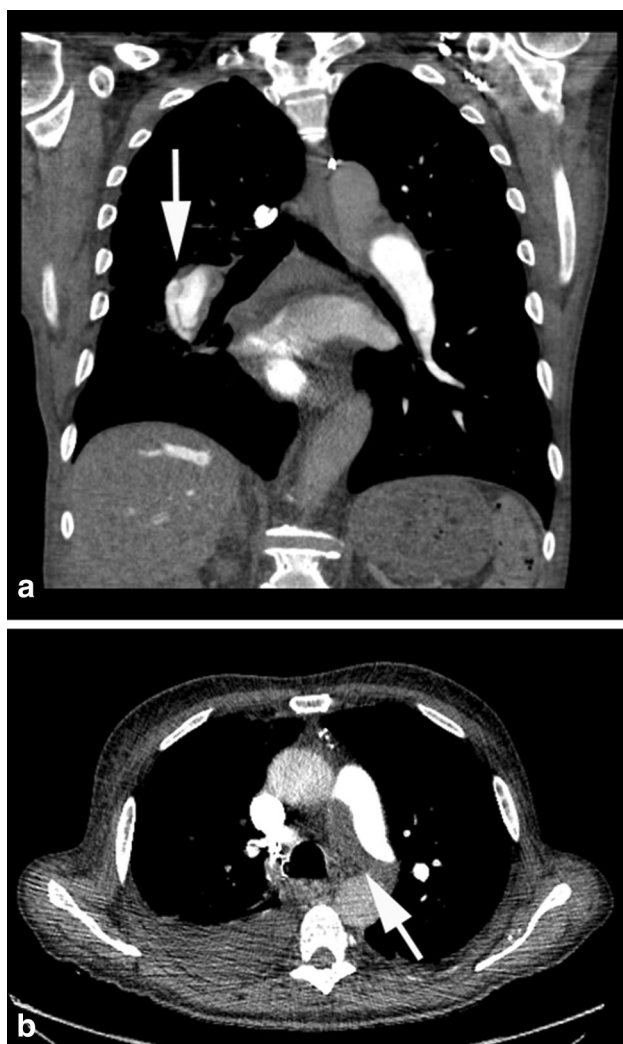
63-year-old man with CTEPH. a Coronal chest computed tomography (CT) demonstrates a web in the right interlobar pulmonary artery (arrow), b axial chest CT demonstrates eccentric thrombus in the left main pulmonary artery (arrow)
